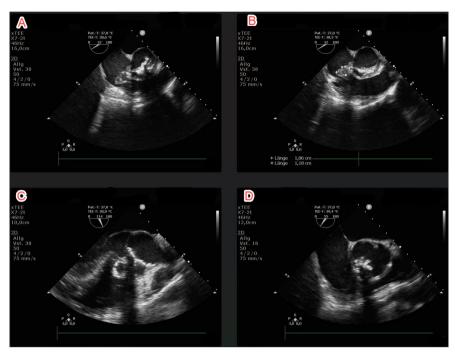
intraoperative trans-oesophageal echocardiography. (A) mid-oesophageal short-axis view demonstrating large vegetation in RA and ruptured/flail leaflet of the bicuspid aortic valve; (B) mid-oesophageal short-axis view shows the dimensions of the vegetation (1.86 cm × 1.18 cm); (C) mid-oesophageal long-axis view demonstrates Gerbode ventricular septal defect; (D) mid-oesophageal right ventricular inflow-outflow view demonstrating the hyperdense vegetation.
